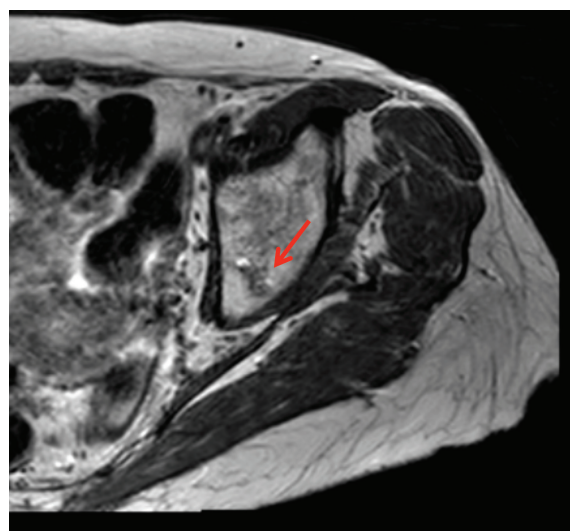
MRI demonstrates an irregular lesion in the left acetabulum suggestive of an intraosseous vascular lesion (arrow).
